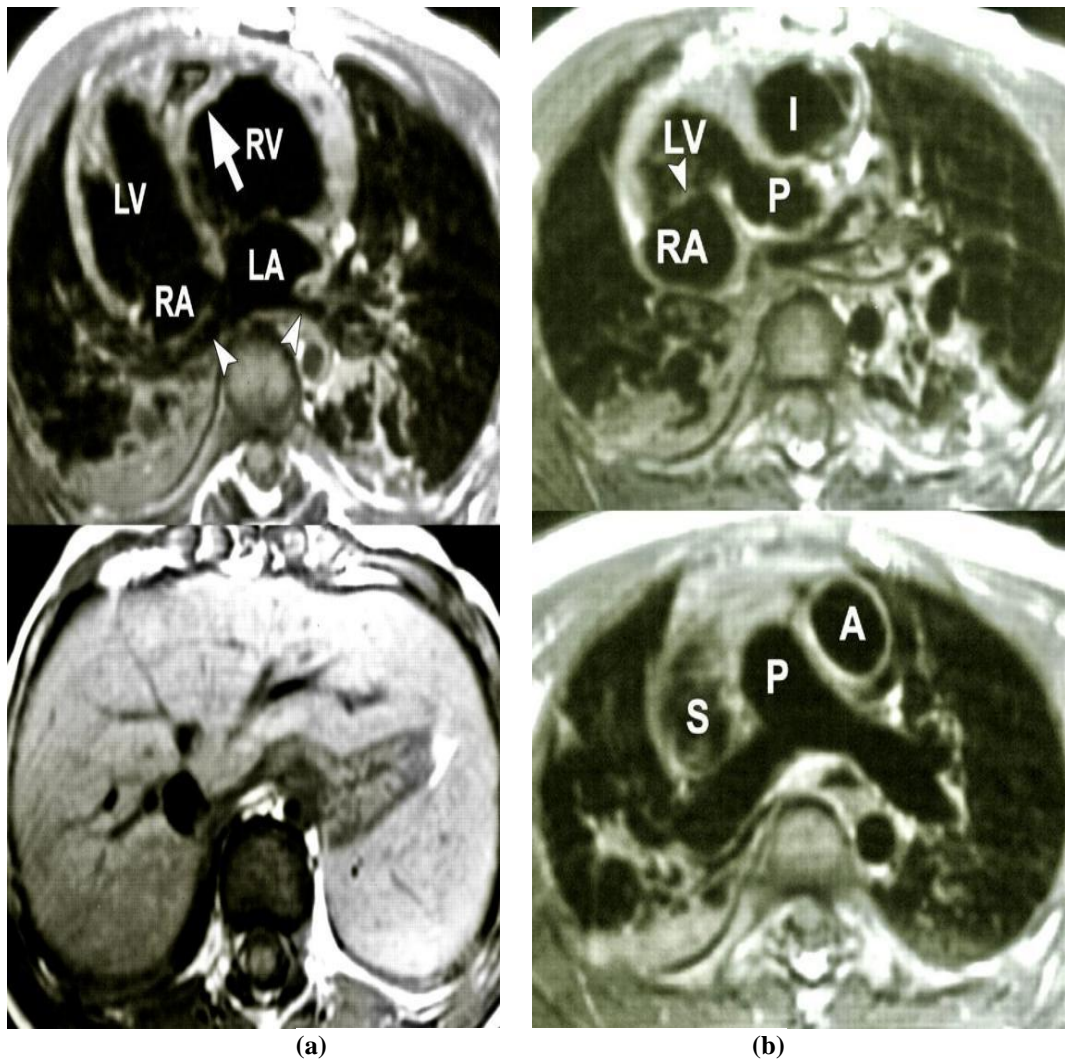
Cardiac MRI depicting Dextrocardia with CCTGA. Cardiac MR images in patient with dextrocardia, situs solitus, and corrected transposition of great arteries (TGA). (a) Liver is on right and spleen is on left (bottom image), revealing situs solitus. Image through cardiac chambers (top image) shows discordant atrioventricular connections. Inferior pulmonary veins (arrowheads) drain to morphologic left atrium (LA). Left atrium is connected to morphologic right ventricle (RV), which is distinguished by presence of a moderator
